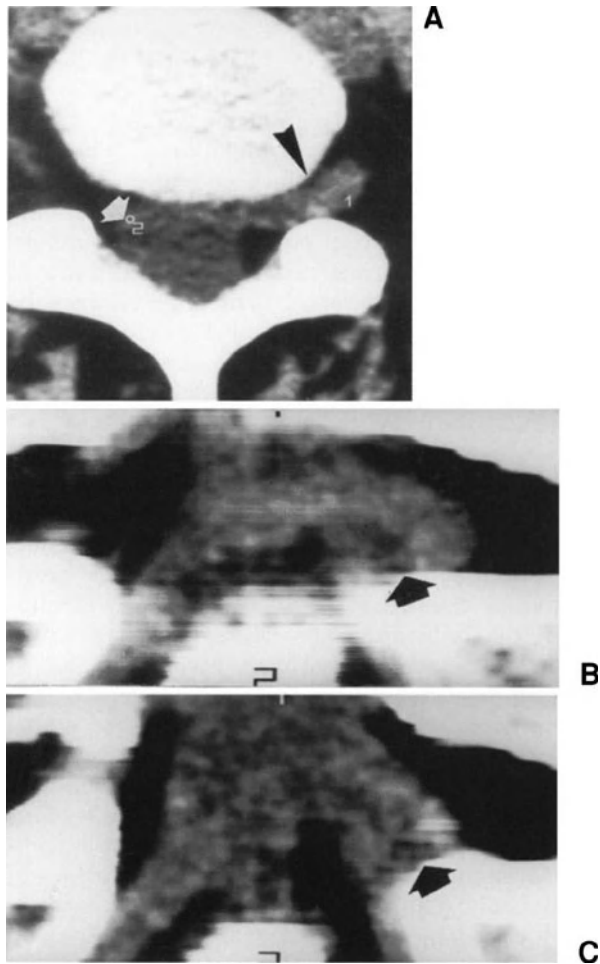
Type-IV nerve-root anomaly of right L5 and S1 nerve roots. (A) Axial CT scan at L5-S1 level. On the left, the L5 root can be seen in the intervertebral foramen (arrowhead), whereas on the right no root is visible in the foramen. On this side, the thecal sac shows an anomalous morphology (arrow) due to the presence of the two roots conjoined. (B) and (C) Coronal reconstructions showing, on the right, an abnormally large nerve trunk (arrows) probably consisting of two conjoined roots (L5 and S1).
